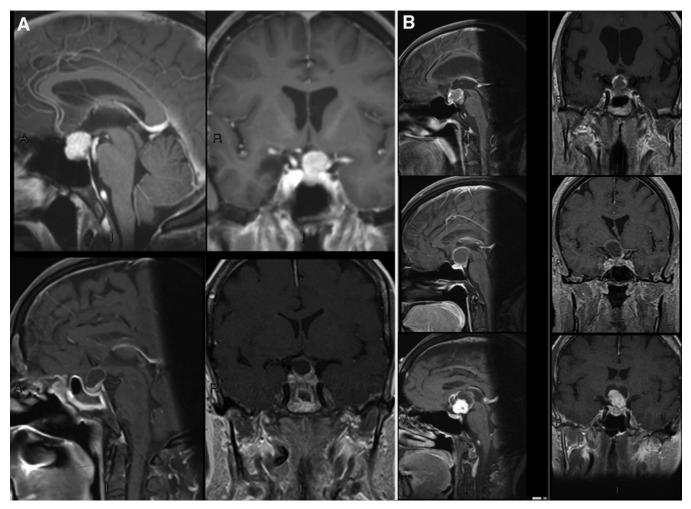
Sagittal and coronal T1-weighted MR imaging with Gd of subdiaphragmatic (A) and supradiaphragmatic (B) tumors.
